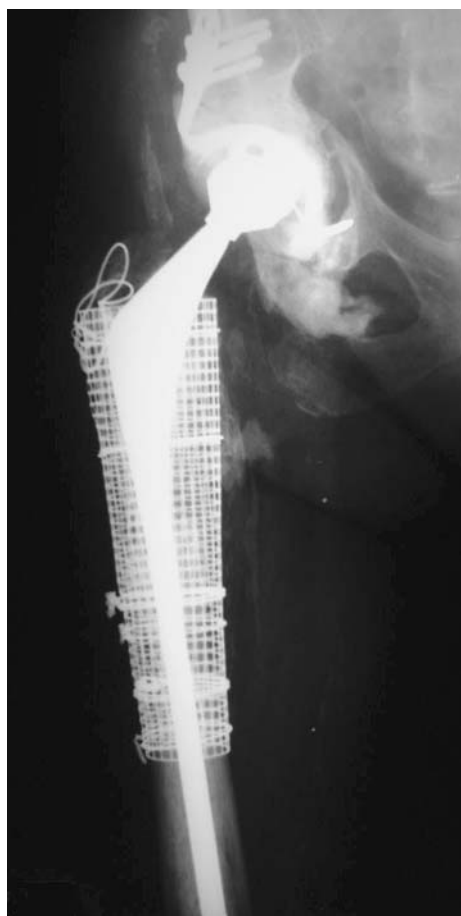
Case 12. Anteroposterior radiograph of the right hip and proximal femur is observed at 5 years postoperatively.
